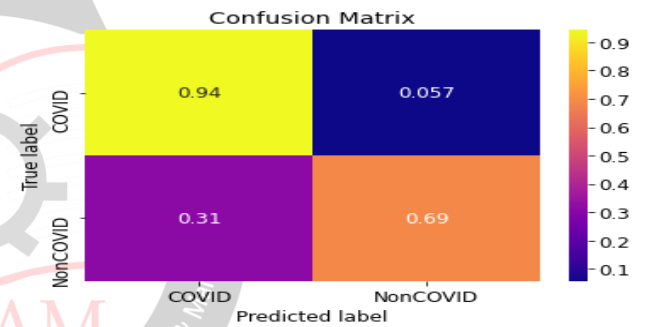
Confusion Matrix of VGG model for CT-Scan images
